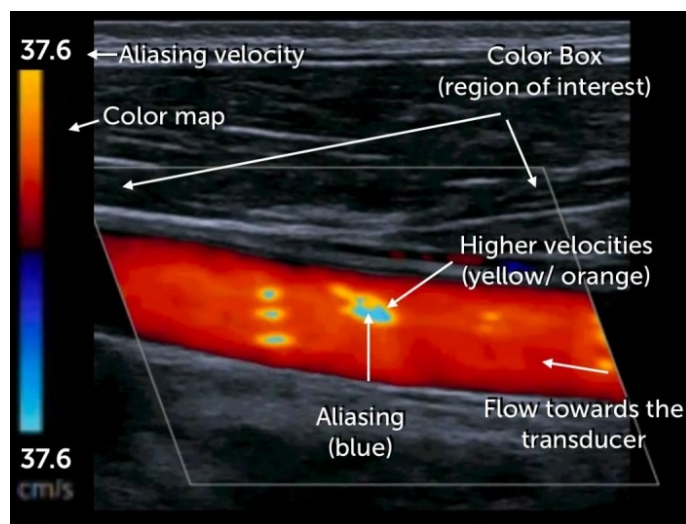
Carotid DUS - information provided by the Color Doppler study*
